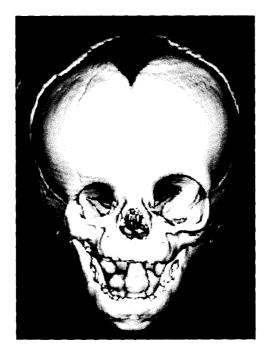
Three-dimensional computed tomography reconstruction of 1-year-old female patient with severe right microphthalmos. Characteristic features on the affected side include a blunted superior orbital rim, a short lateral orbital rim, a malar bone higher than that on the opposite side, and mild facial scoliosis.
